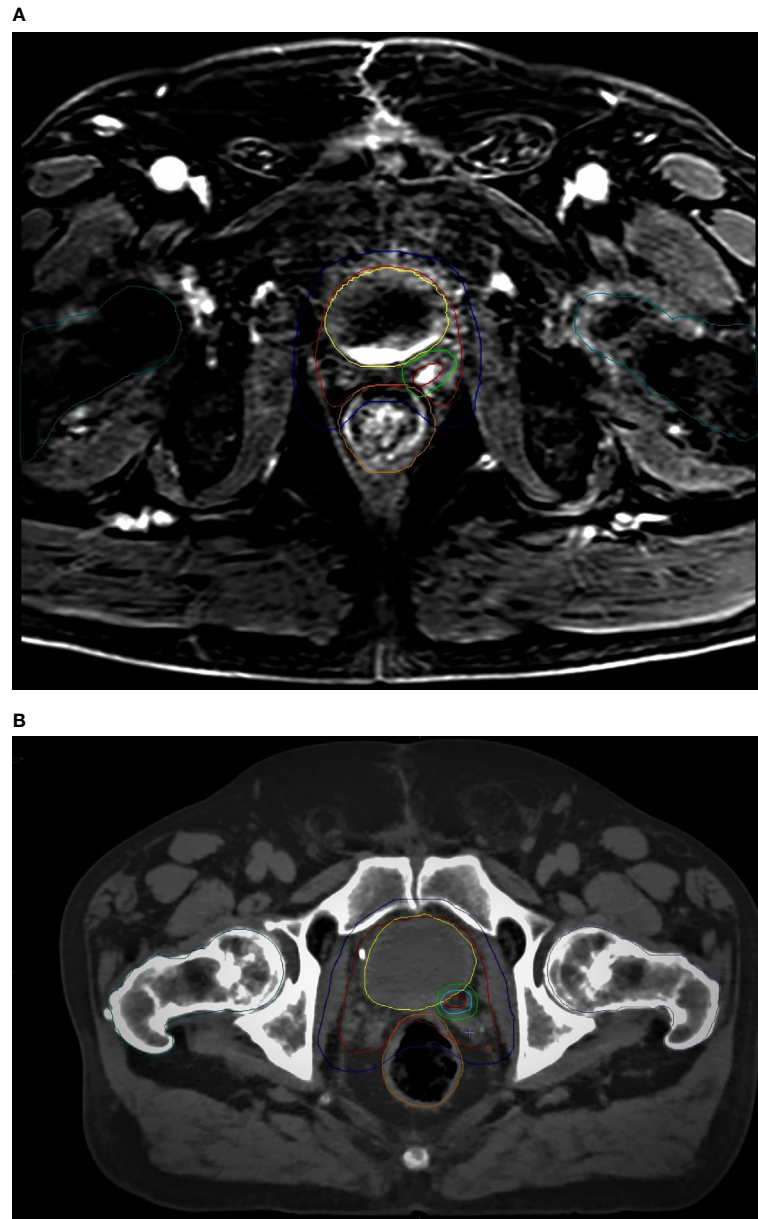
mpMRI-based (A) vs CT-based (B) CTV/PTV (prostate bed) and OARs delineation: red, CTV (prostate bed); blue, PTV (prostate bed); yellow, bladder; orange, rectum; dark green, femoral heads.
